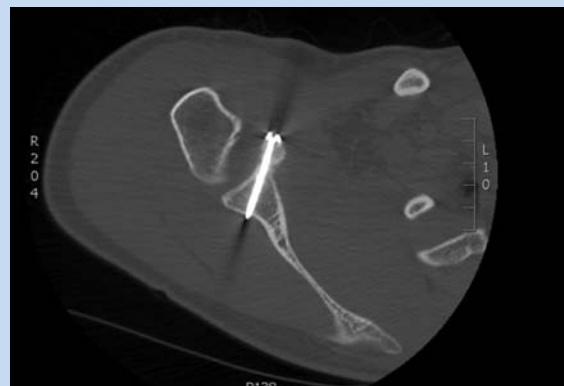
Computed tomography image of glenoid after bone augmentation with Latarjet procedure.
